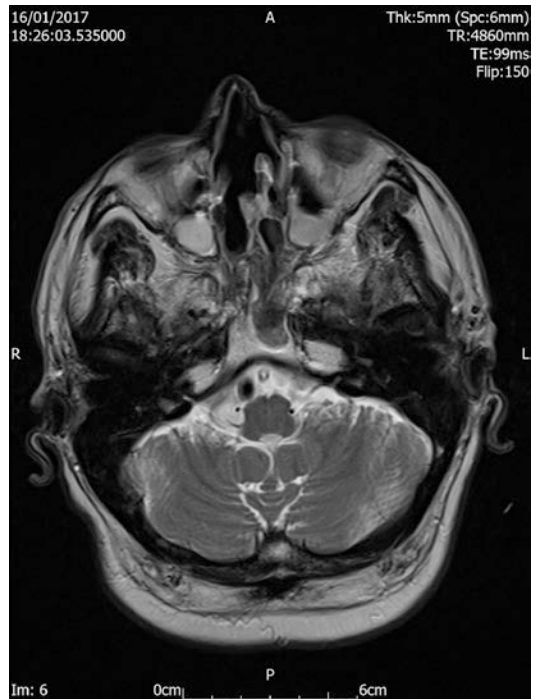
Axial MRI scan with no evidence of disease following the treatment of the recurrent malignant melanoma with endoscopic excision and postoperative radiotherapy
